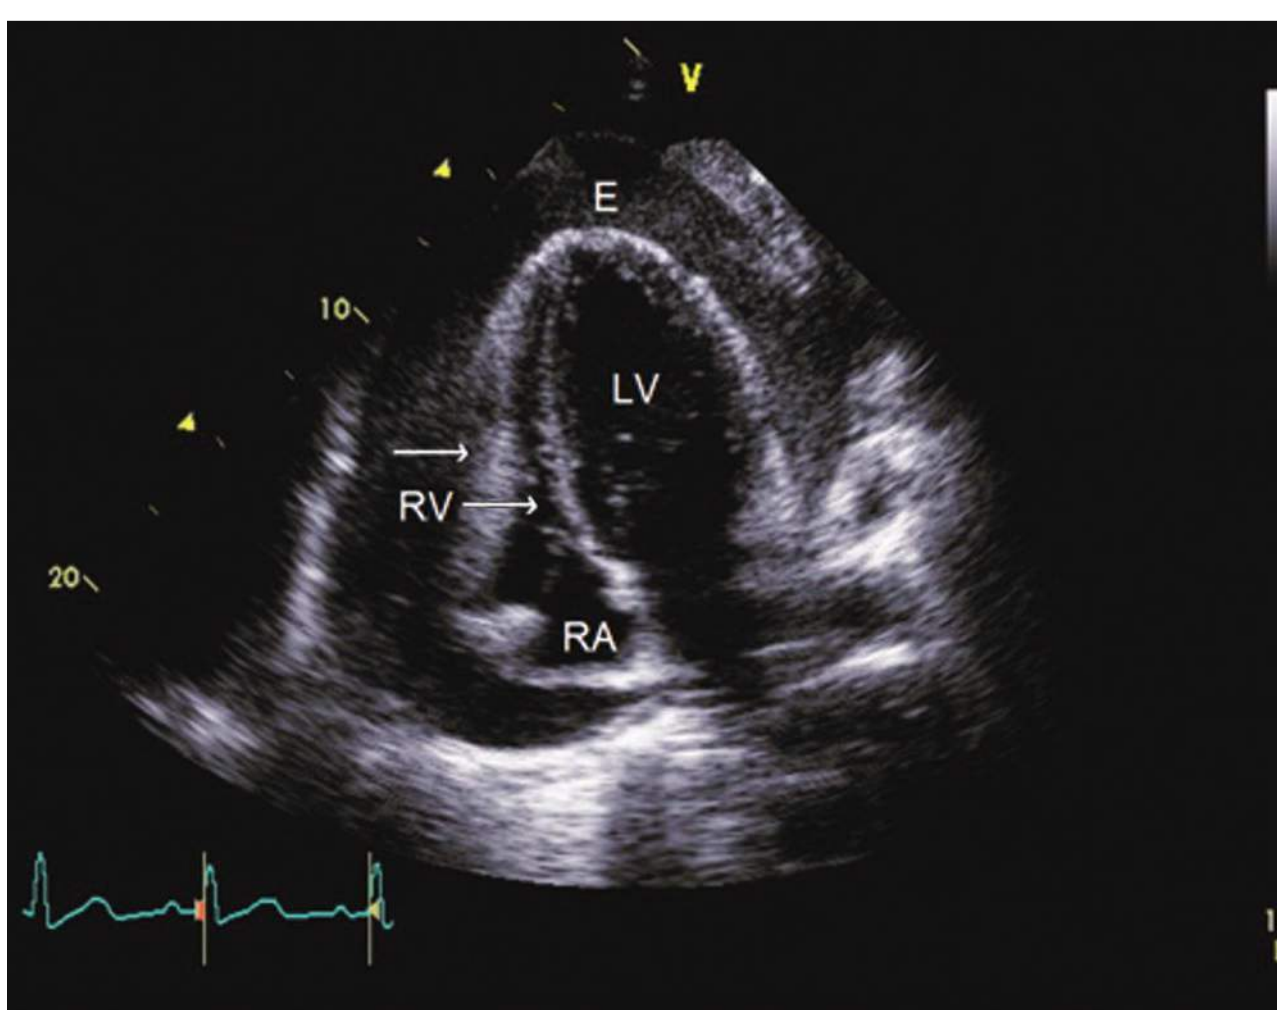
RV compression (arrow) in cardiac tamponade (apical four-chamber plane). RA, right atrium; RV, right ventricle; LV, left ventricle; E, effusion. (Reproduced with permission from Fuster V, Walsh RA, Harrington RA: *Hurst's the Heart*, 13th edition. New York: McGraw-Hill Inc; 2011.)
